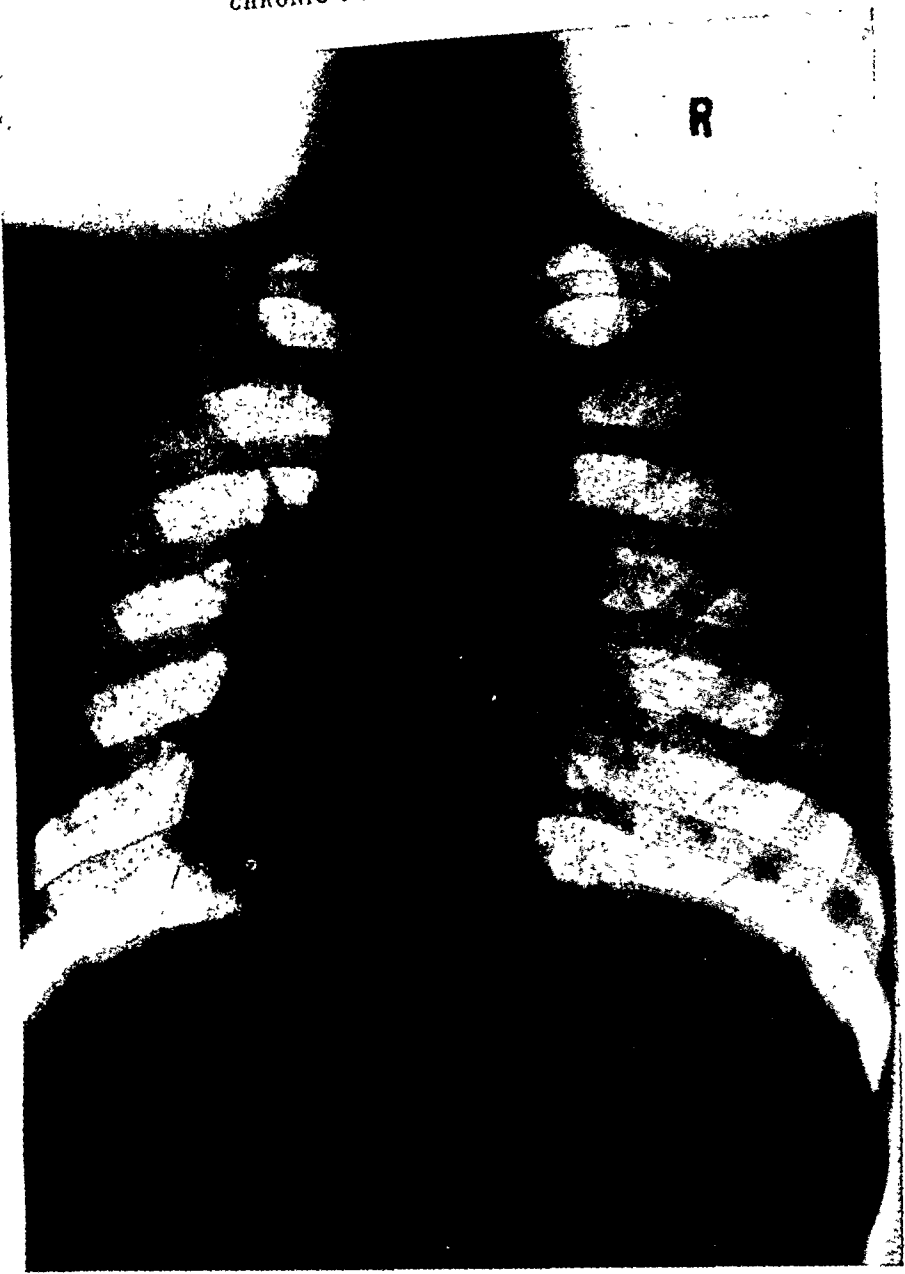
Radiograph of the lungs in a case of Besnier-Boeck's disease: typical broadened hilar shadows, reticular pattern in both lungs.
